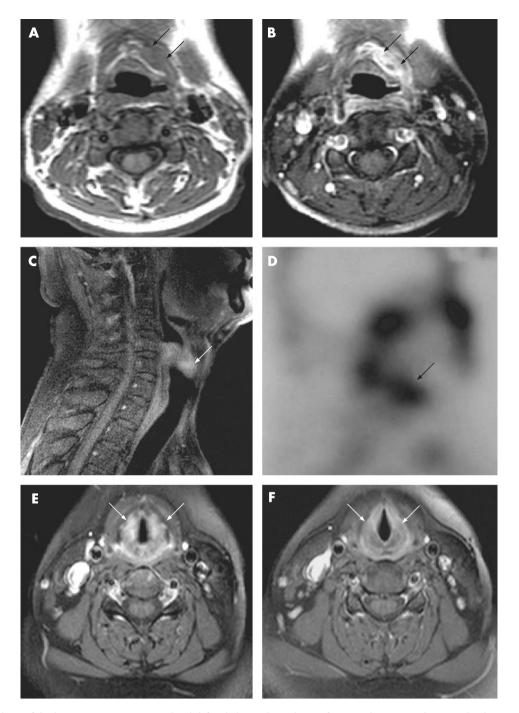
MRI findings of the larynx in case 1 presented with left-sided sore throat lasting for 2 weeks. (A) Axial, T_1 -weighted image shows increased thickness of soft tissue near the left half of the thyroid cartilage (arrows). (B) Post-contrast T_1 -weighted image demonstrates marked enhancement at the same region (arrows). In case 5, presenting with odynophagia, the sagittal plane of the post-contrast T1-weighted image (C) shows an increase in thickness with marked enhancement at the soft tissue near the cricoid-thyroid cartilage and the pharynx (arrow). In this patient, Gallium-67 scintography (D) shows increased uptake intensity at the corresponding region (arrow). A change in MRI findings after effective therapy was observed in case 6. The axial plane of the post-contrast T1-weighted image shows increased thickness with marked enhancement at the soft tissue near the vocal cord in the active phase (E, arrows), and it resumed to normal appearance at the same area (F, arrows) after 5 months' therapy in this patient.
